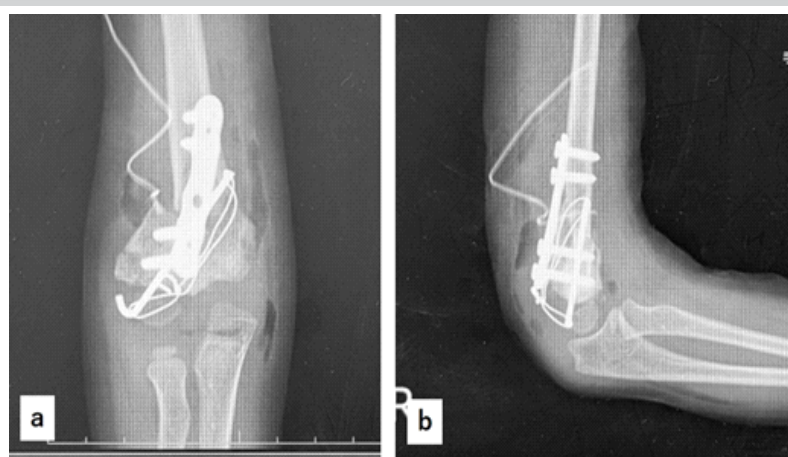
X-ray findings after the first surgery. (a): Anteroposterior view, (b): Lateral view.
